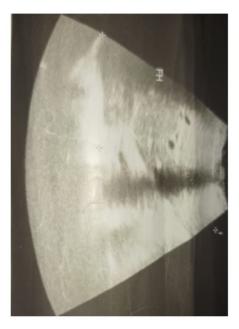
An abdominal ultrasound showed a dysmorphic liver with enlarges segment I and atrophy of its right posterior sector with no focal lesion.
